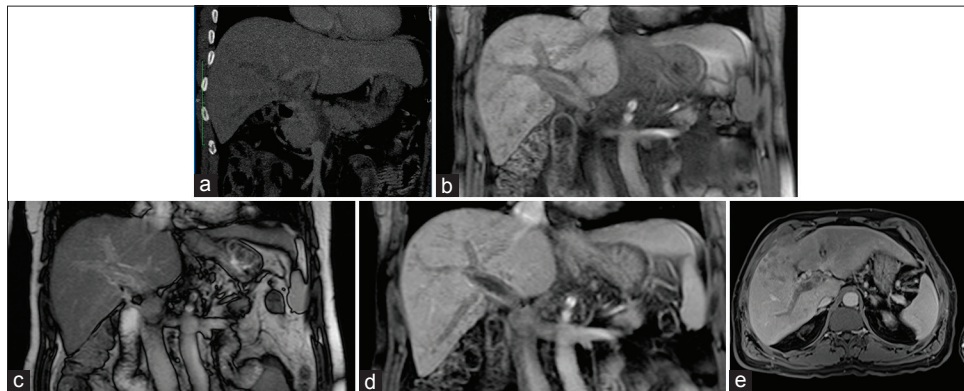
An enhanced coronal CT image (hepatic venous phase) (a) coronal unenhanced T1 and T2 weighted image (b and c) Coronal enhanced T1 weighted image (equilibrium phase) (d) and axial enhanced T1 weighted images (equilibrium phase) reveal heterogeneously enhanced lesion fulfilling the portal vein and increasing in caliber of portal veins (e)
